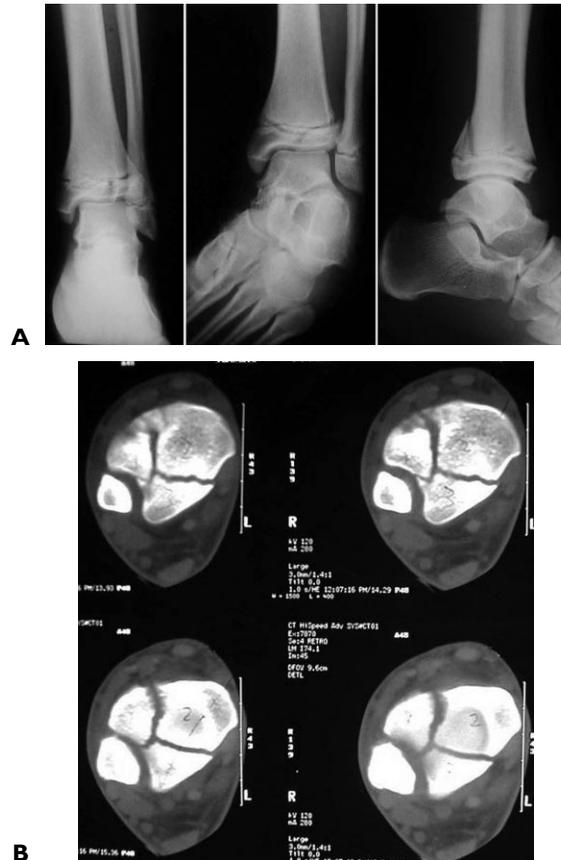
(A) Radiograph and (B) computed tomography scans of the left ankle of the patient described in questions 1 and 2.
